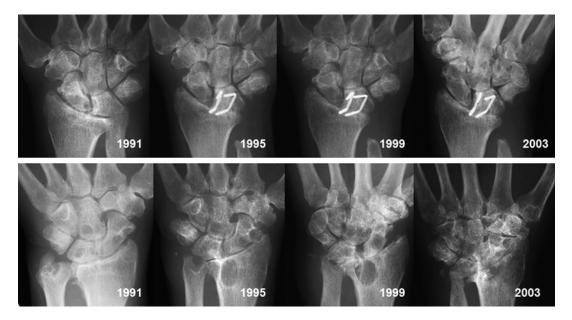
Serial radiographs of the wrist with RL fusion (*upper row*) and the wrist without surgical treatment (*lower row*) in the same patient with RA. *RL* radiolunate
